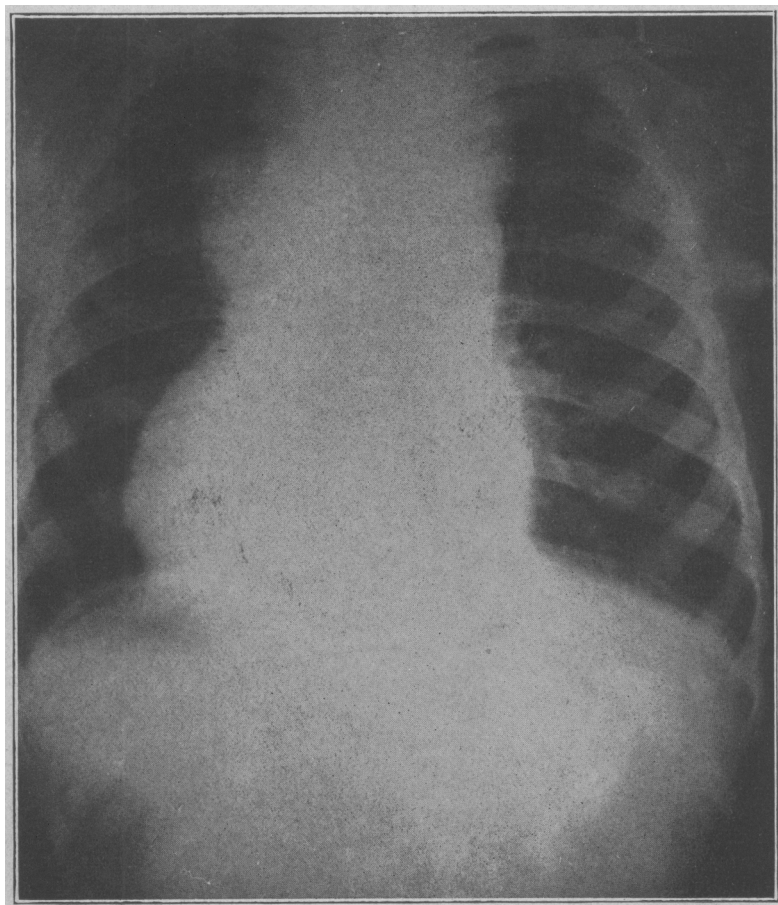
Roentgenogram of tumor, taken during life by Dr. Percy Brown.
